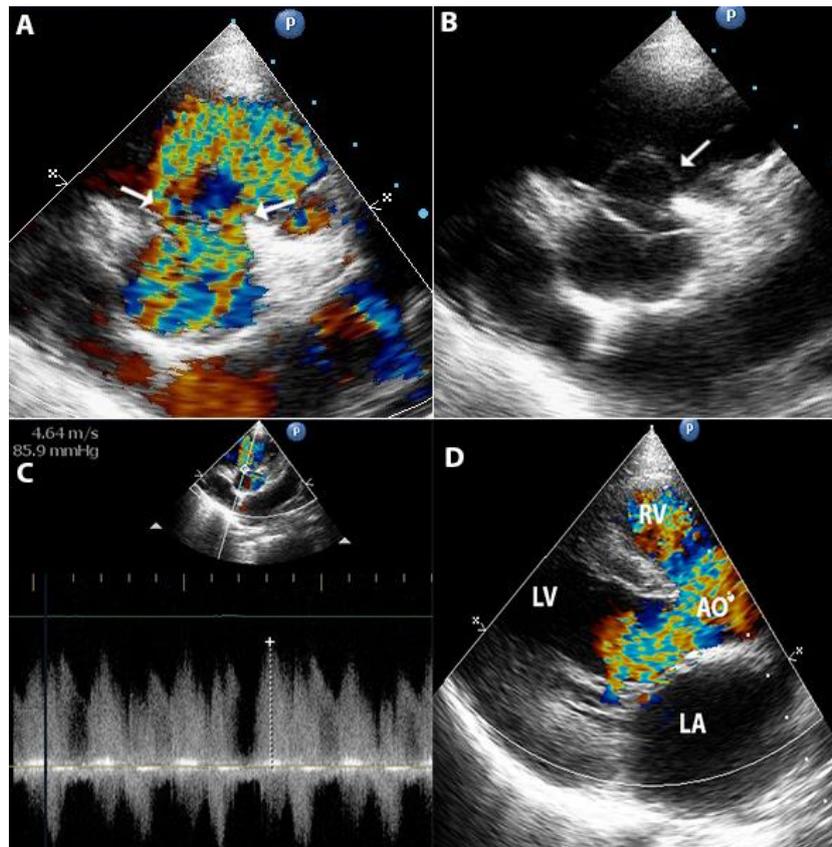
1(A) Short axis view on Colour doppler echocardiography shows ruptured sinus of valsalva aneurysm through right coronary cusp of aortic valve. 1(B) Short axis shows aneurysm of right coronary cusp with characteristic “windsock” deformity. 1(C) Doppler study shows continuous flow through defect with a pressure gradient of 85 mm Hg. 1(D) Long parasternal view shows severe aortic regurgitation and flow through ventricular septal defect.
